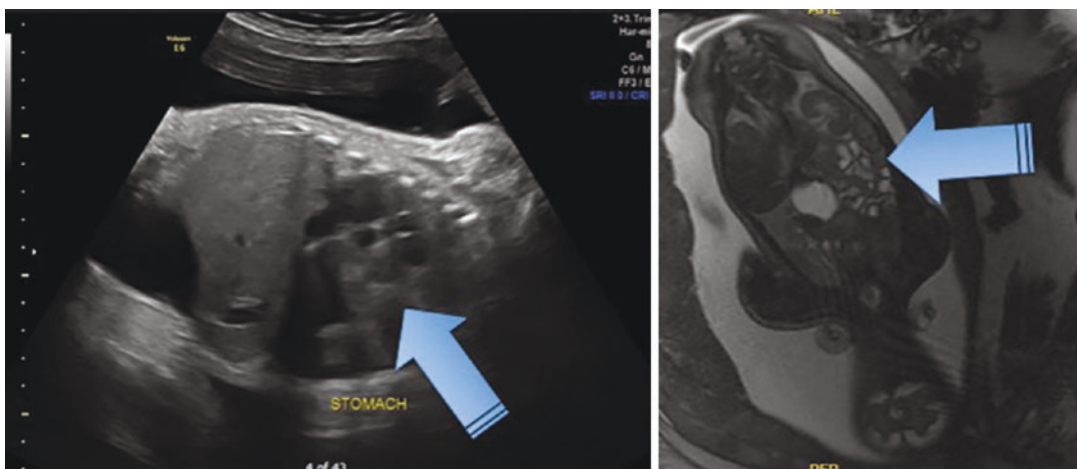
Ultrasound (left) and MRI (right) images revealing Bochdalek hernia in an infant in utero. The arrows point to the stomach and intestine in the left hemithorax
